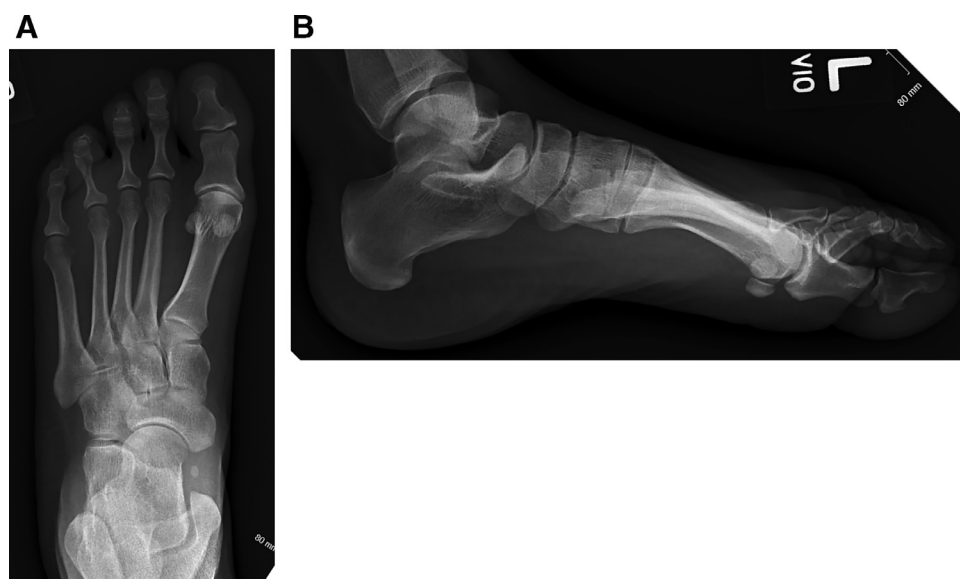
(a,b) Anterior posterior and lateral radiographs of the left foot during current encounter again show a nonspecific soft tissue density overlying the third and fourth metatarsal heads. There is no soft tissue calcification, radiodense foreign body, osseous erosion, or periosteal reaction.
